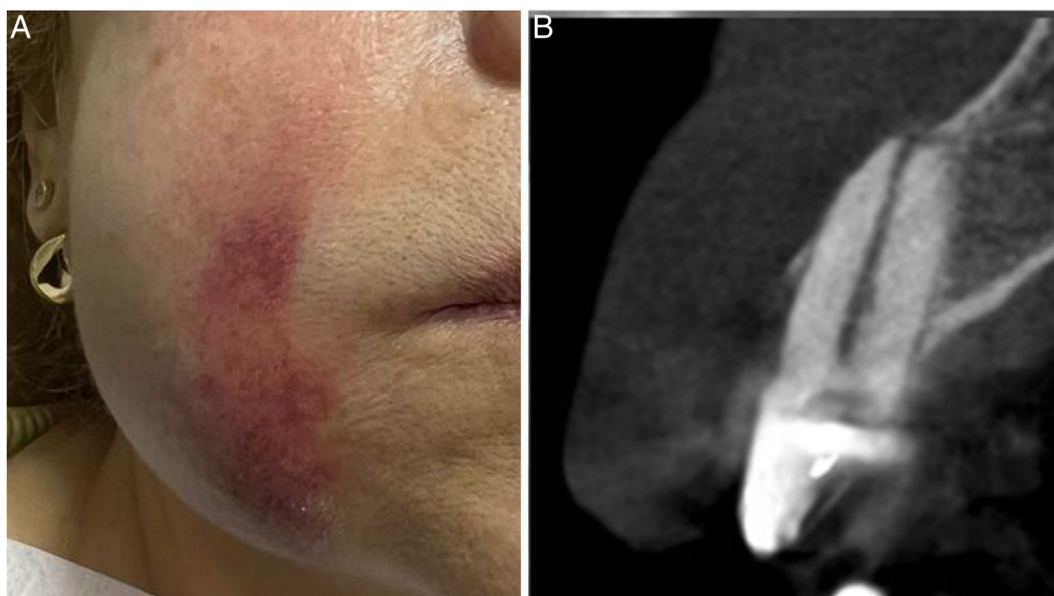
A and B - Clinical presentation and cone-beam computed tomography (CBCT) imaging of a sodium hypochlorite accident. (A) Extraoral photograph showing diffuse facial swelling and periorbital ecchymosis on the affected side within hours of the incident. (B) Sagittal CBCT slice revealing apical root fenestration.
